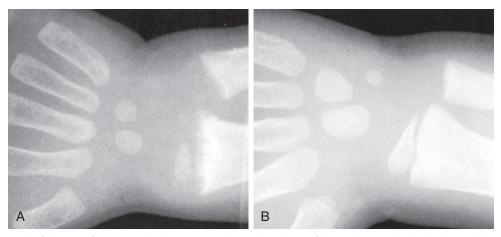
Rickets. Radiograph of the wrist of a patient with rickets. A, Irregularity and widening of the epiphyses in the distal radius and ulna. B, With appropriate therapy, remineralization and healing occur.
